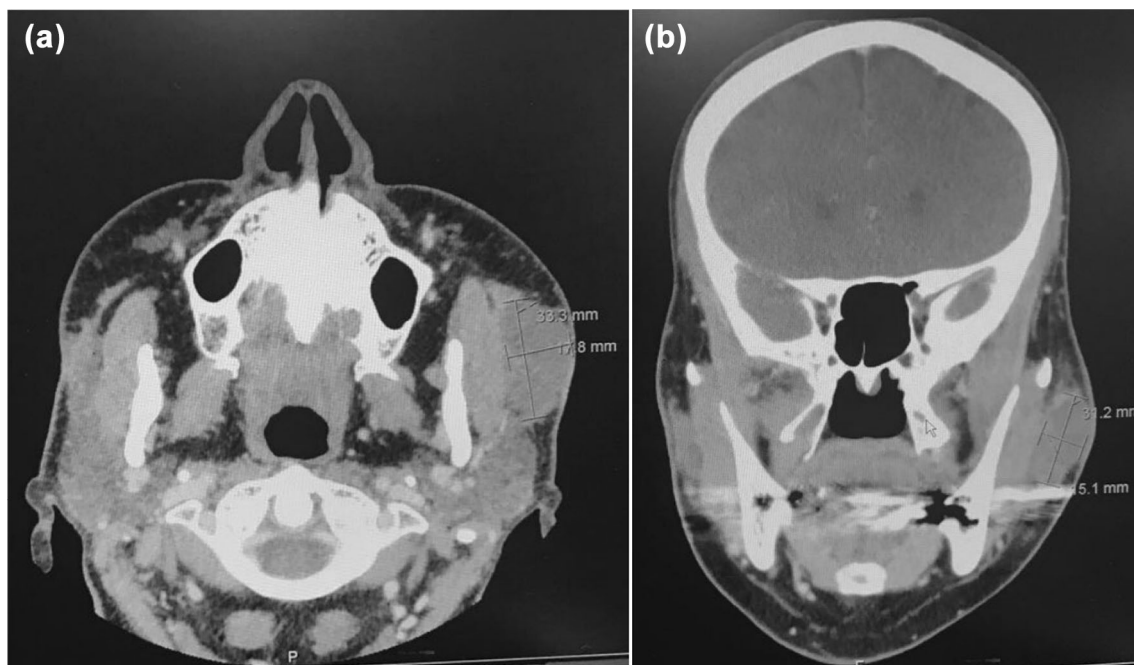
a, b CT axial and coronal views showing large fluid collection on the left side with mild peripheral enhancement and inflammatory changes on the right side
